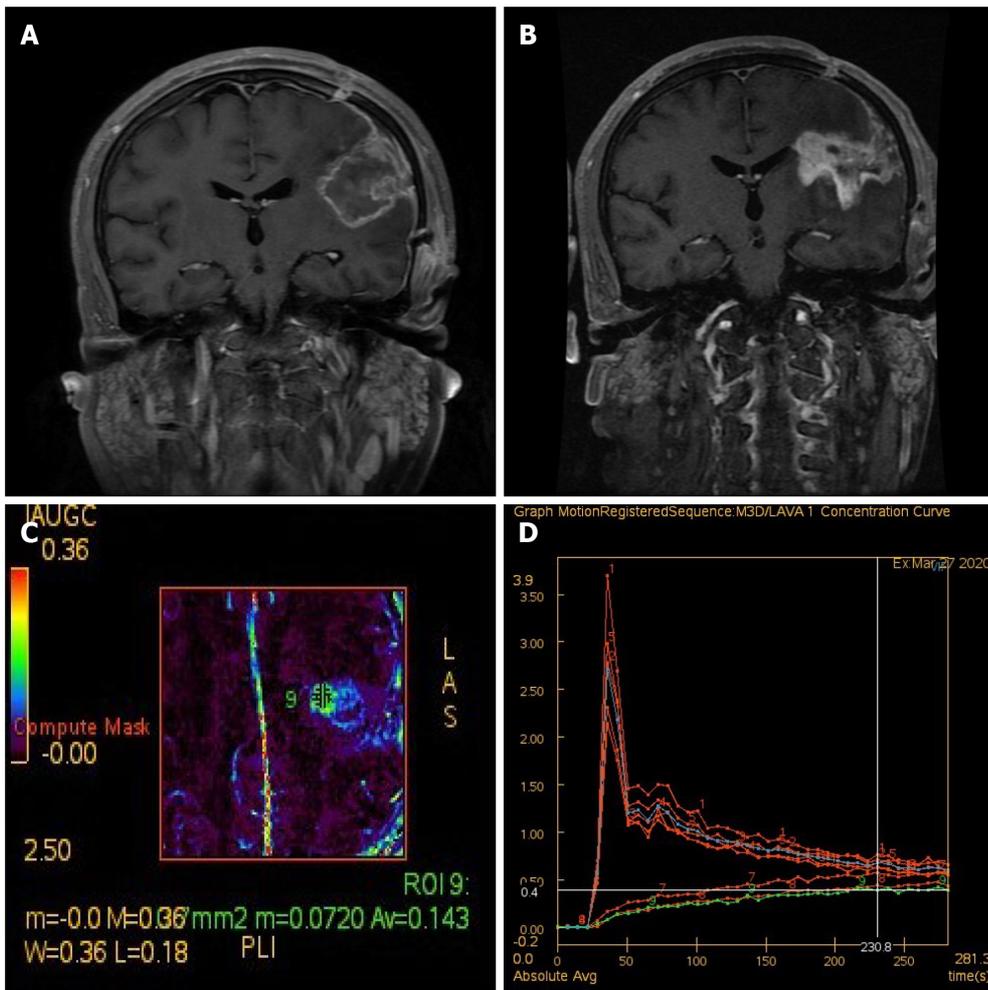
Imaging changes after treatment of synovial sarcoma. A: Enhanced T1-weighted imaging (T1WI) after craniotomy indicated tumor removal; B-D: Perfusion-weighted imaging 6 mo after craniotomy (3 mo after radiotherapy). Enhanced T1WI indicated that the lesion was larger than before (B). Analysis of the enlarged part of the lesion (the area marked by 9 in C) suggested that the enlarged lesion is hypoperfusion, and radiation necrosis was considered (C and D).
